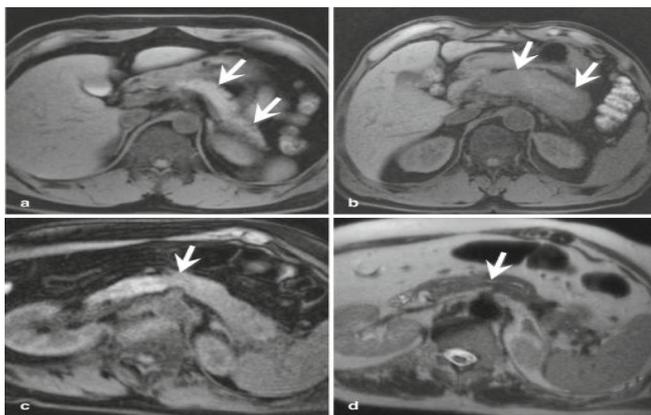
MRI images of Pancreas with Benign tumor
